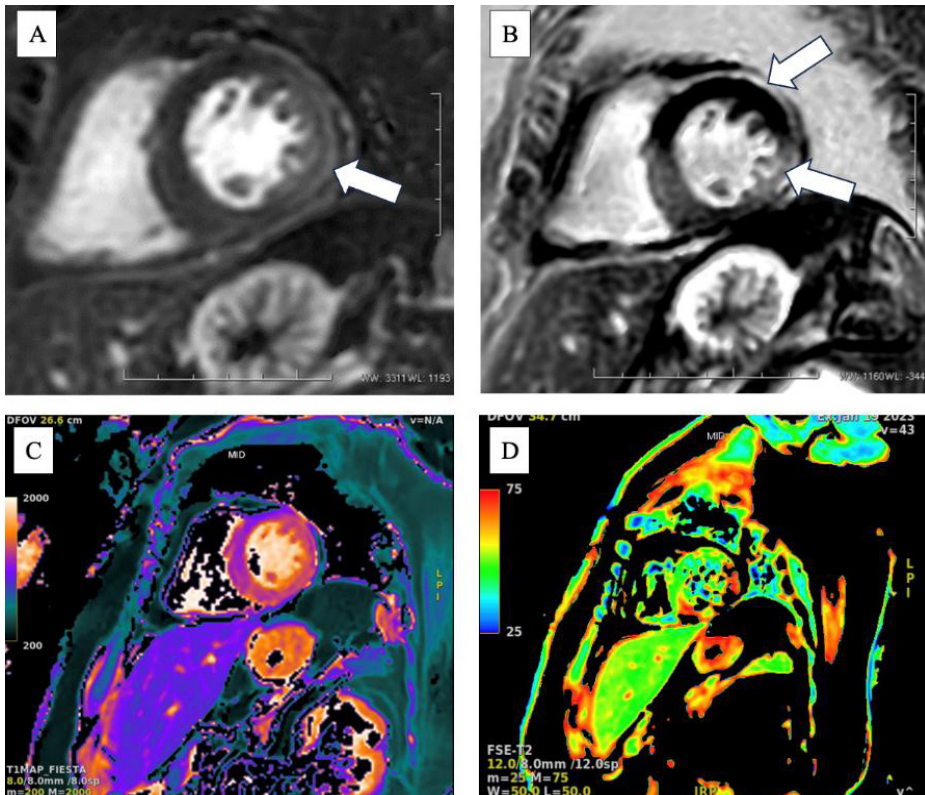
MRI results. A, B. LGE showed non-ischemic pattern of hyperenhancement involving midmyocardium in the lateral wall extending to anterior wall (white arrow). C. T1-mapping showed area with increase native T1 value in the midmyocardium. D. T2-mapping showed increased T2 value in the corresponding area.
